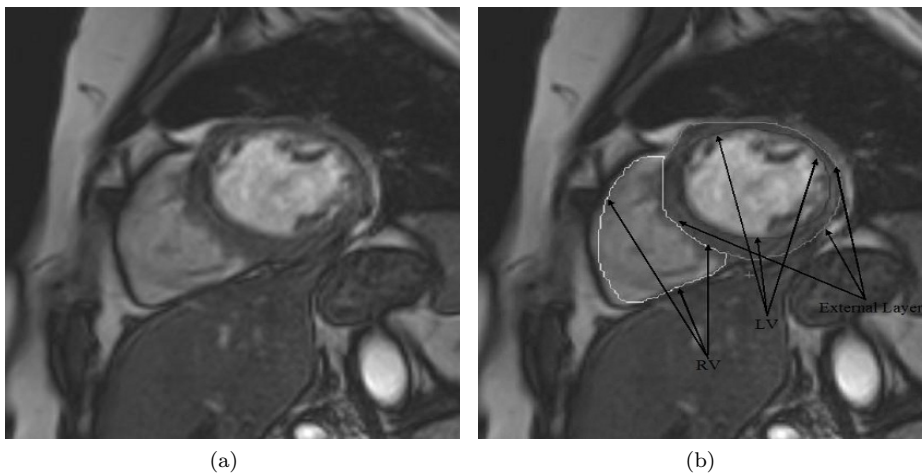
(a) Original MR image of a patient. (b) Left ventricle cavity with trabecules (black delimited zone, identified as LV), right ventricle cavity (white delimited zone, identified as RV) and external layer (gray and white line, identified as External Layer).
